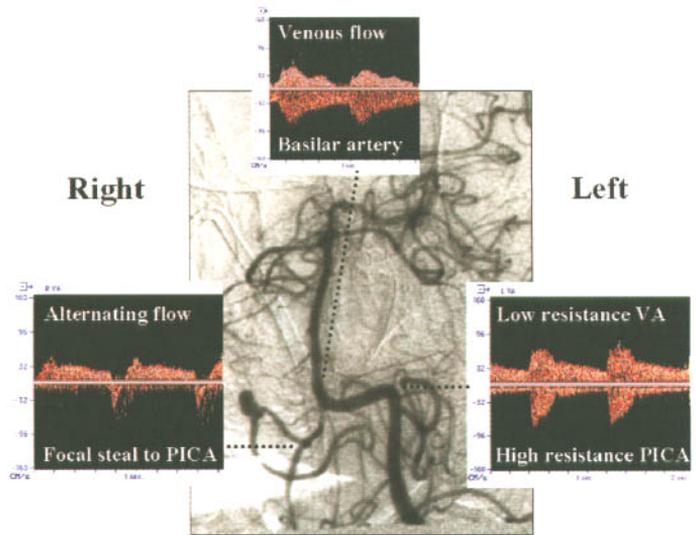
Transcranial Doppler waveforms, retrograde filling of the right vertebral artery and posterior inferior cerebellar artery aneurysm.
